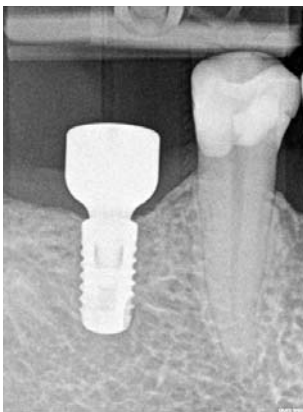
X-ray after placement of healing abutment
